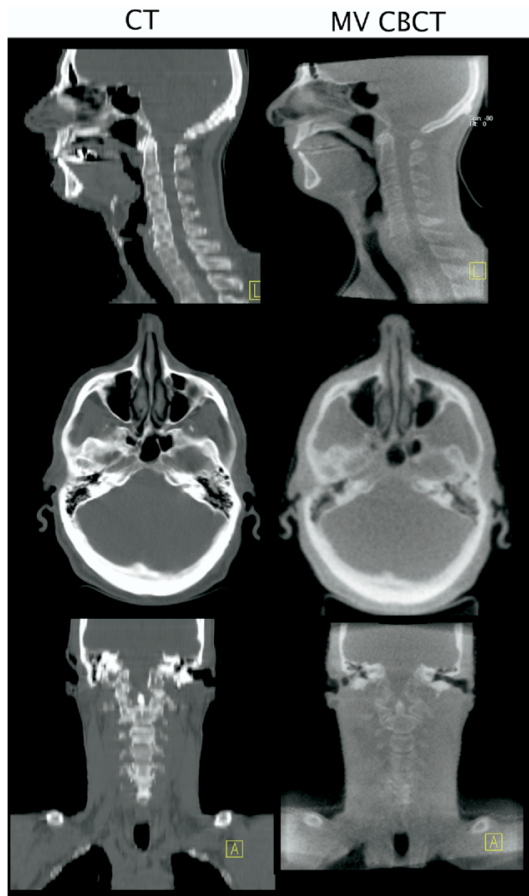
Comparison of a diagnostic CT (left) with a 7-MU MV CBCT (right) for a typical head-and-neck patient. The window level of both sets of images was adjusted to provide the best soft-tissue contrast.
